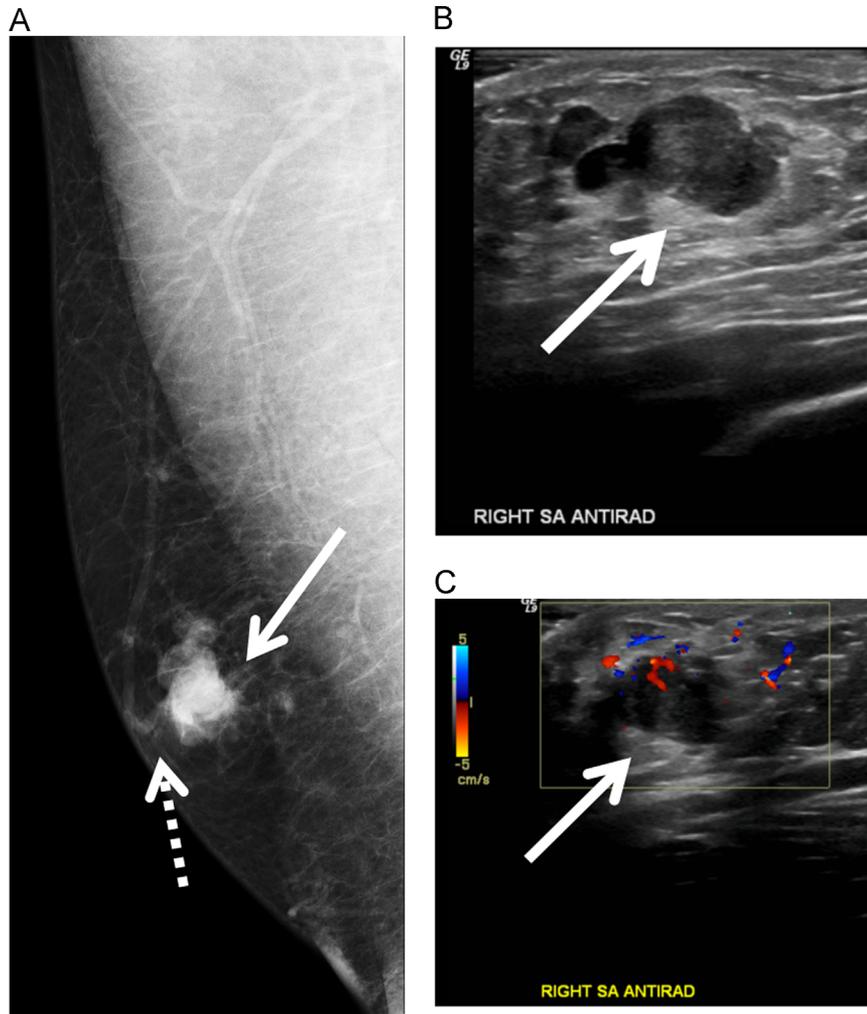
A 31-year-old male presents with a palpable abnormality in the right breast. MLO mammogram (A) shows a high density irregular mass in the right breast (solid arrow) with a clear fat plane between the nipple and the mass (dotted arrow). US (B) demonstrates a corresponding mass (arrow) with vascularity, as seen on color Doppler imaging (C). US-guided biopsy showed invasive ductal carcinoma. The patient subsequently underwent right mastectomy. MLO mammogram (D) shows mild left breast gynecomastia (arrow). Note that there is absence of a fat plane between the gynecomastia and the nipple in contrast to the malignant mass seen in (A). Sagittal and axial postcontrast T1-weighted images with fat suppression (E and F) for high-risk screening demonstrate corresponding mild left breast gynecomastia (solid arrows) and postsurgical changes due to the right mastectomy (dotted arrow). (Color version of the figure available online.)
